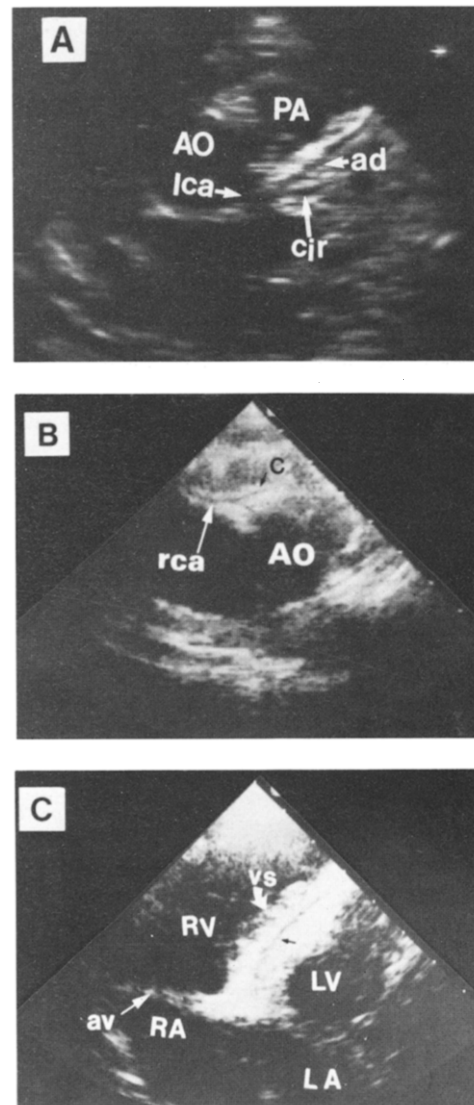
Echocardiographic views of normal coronary arteries. A, Left parasternal short-axis view demonstrating normal left main (lca), left anterior descending (ad) and circumflex (cir) coronary arteries. B, High modified right parasternal short-axis view demonstrating a small conal branch (c) originating from the right coronary artery (rca). This branch could not be traced to or seen in the right ventricular outflow tract. C, Modified apical four chamber view with posterior and lateral angulation and minimal clockwise rotation of the transducer demonstrating a normal left anterior descending coronary artery (small black arrow) coursing through the ventricular septum (vs). AO = aorta; av = atrioventricular groove; LA = left atrium; LV = left ventricle; PA = pulmonary artery; RA = right atrium; RV = right ventricle.
